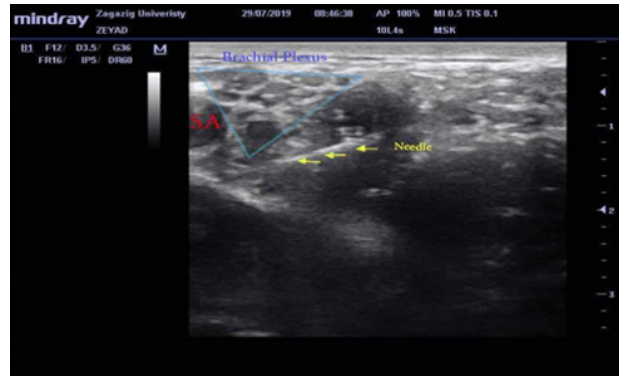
Ultrasound image showing the needle "yellow arrows" directed to the angle in between the first rib and the subclavian artery "SA"
